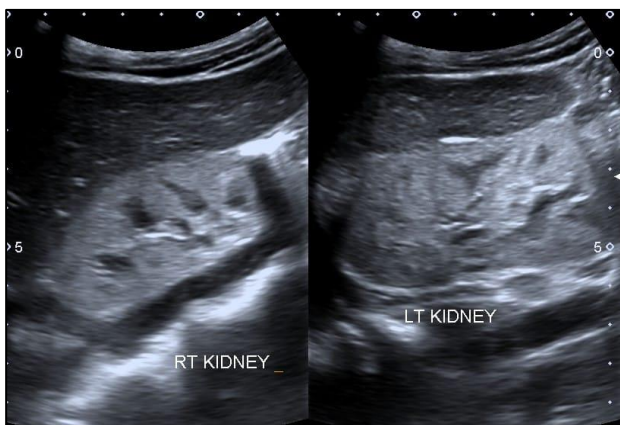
USG Whole abdomen showing bulky left kidney taking increased vascularity on colour doppler suggest possibility of pyelonephritis, non-visualised spleen, bilateral raised renal echotexture.
